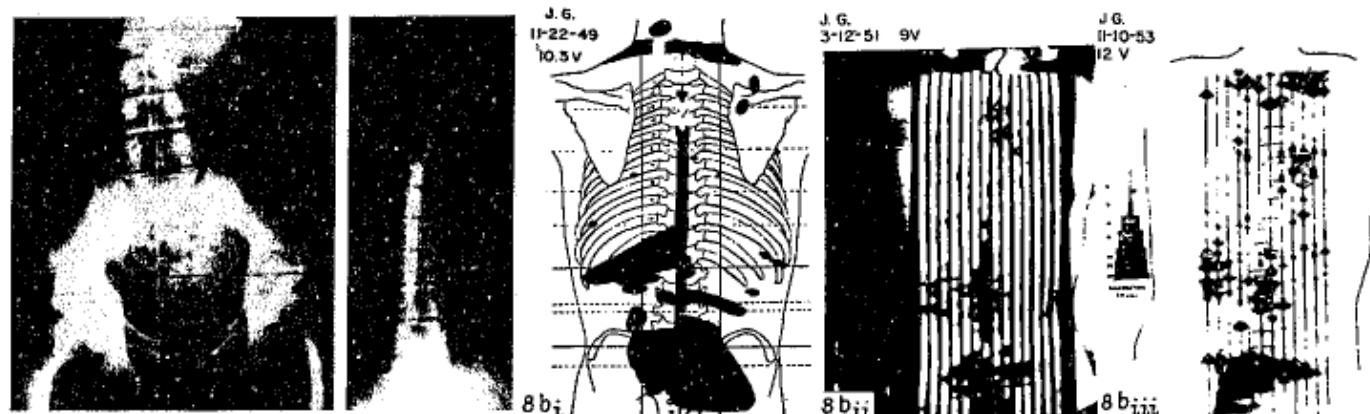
a. Radiographs of patient J.G., standing (see text, Case 8).
